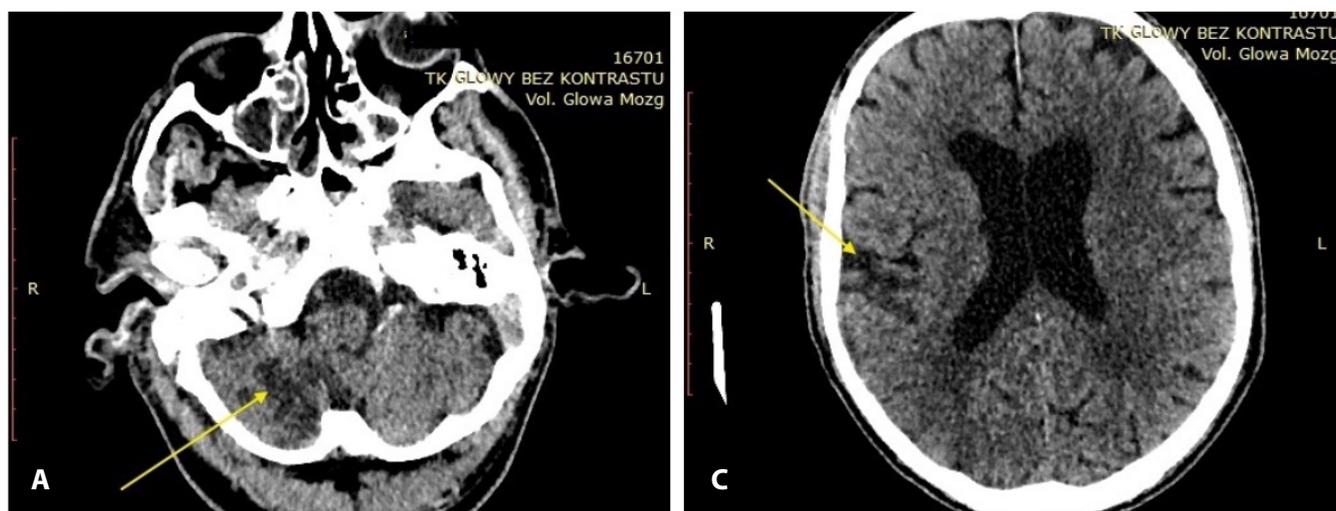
A: Head axial CT. Infarction of the right hemisphere of the cerebellum (arrow). B: Head axial CT. Infarction of the right parietal lobe (arrow).
